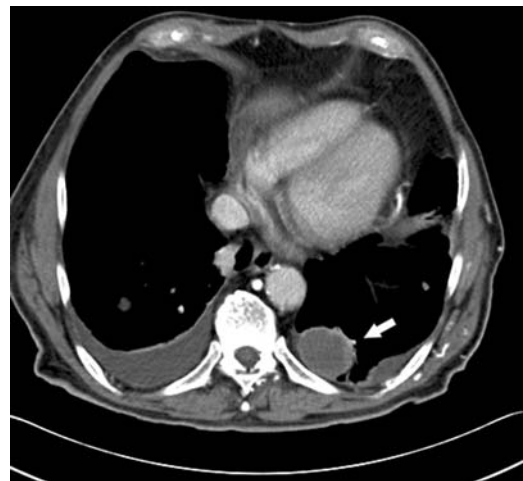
Computed tomography of the thorax of a patient with undifferentiated thyroid cancer demonstrating a 2.5-cm pulmonary metastasis posteriorly within the lower lobe of the left lung (*arrow*). A smaller metastasis within the posterior right lower lobe is also seen.
